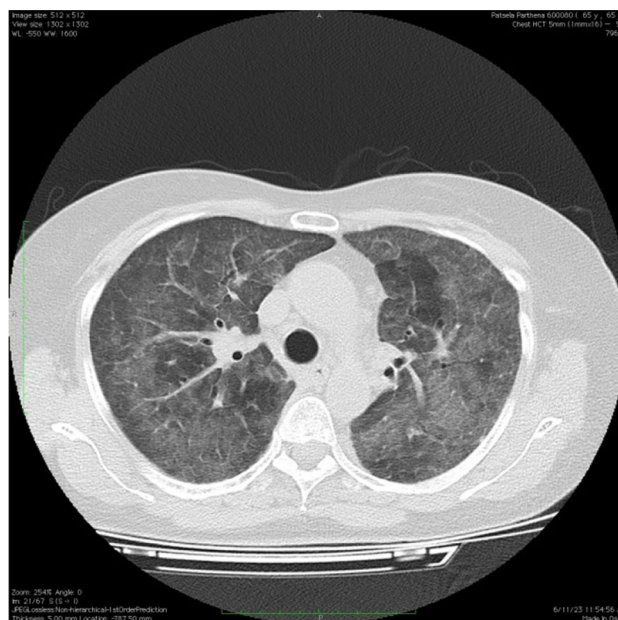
Ground-glass pattern in HRCT
